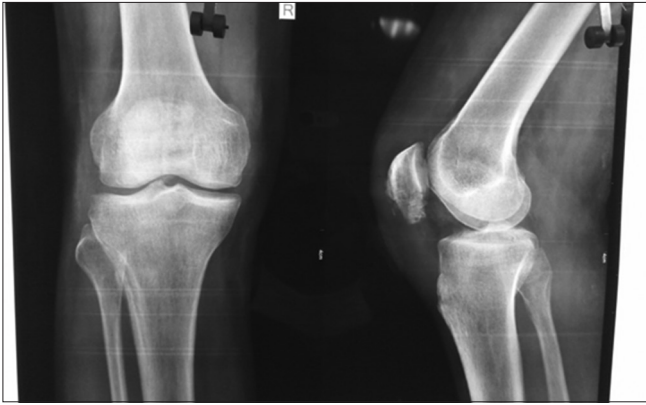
Pre-operative radiograph showing comminuted lower pole patella fracture
